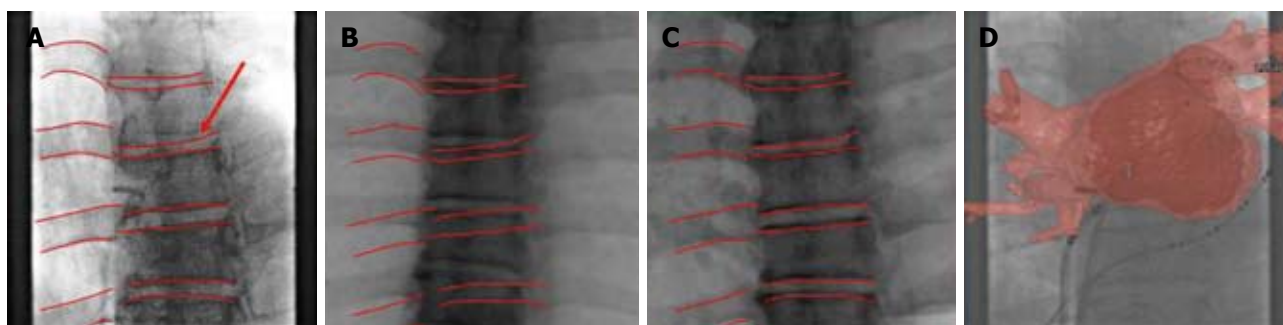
Spine-based 2-D/3-D registration examples for electrophysiology^[9]. A: Spine-enhanced fluoroscopy with the edge contours depicted; B: Digitally reconstructed radiographs (DRRs) before registration overlaid with the edge contours from fluoroscopy; C: DRRs after registration overlaid with the edge contours from fluoroscopy; D: 2-D/3-D overlay used for electrophysiology procedures. The 3-D mesh model is generated from the segmentation of the left atrium and pulmonary veins, and is overlaid with fluoroscopy by the proposed spine-based 2-D/3-D registration technique.
